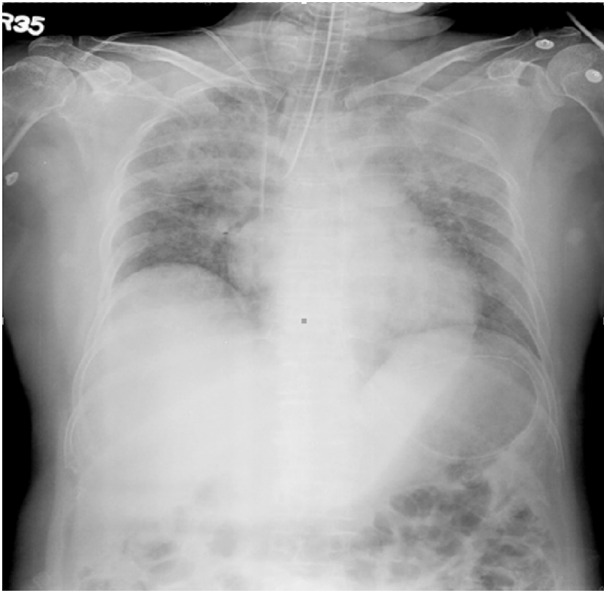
Initial chest X-ray of the patient showing insertion of the nasogastric tube into the stomach.
